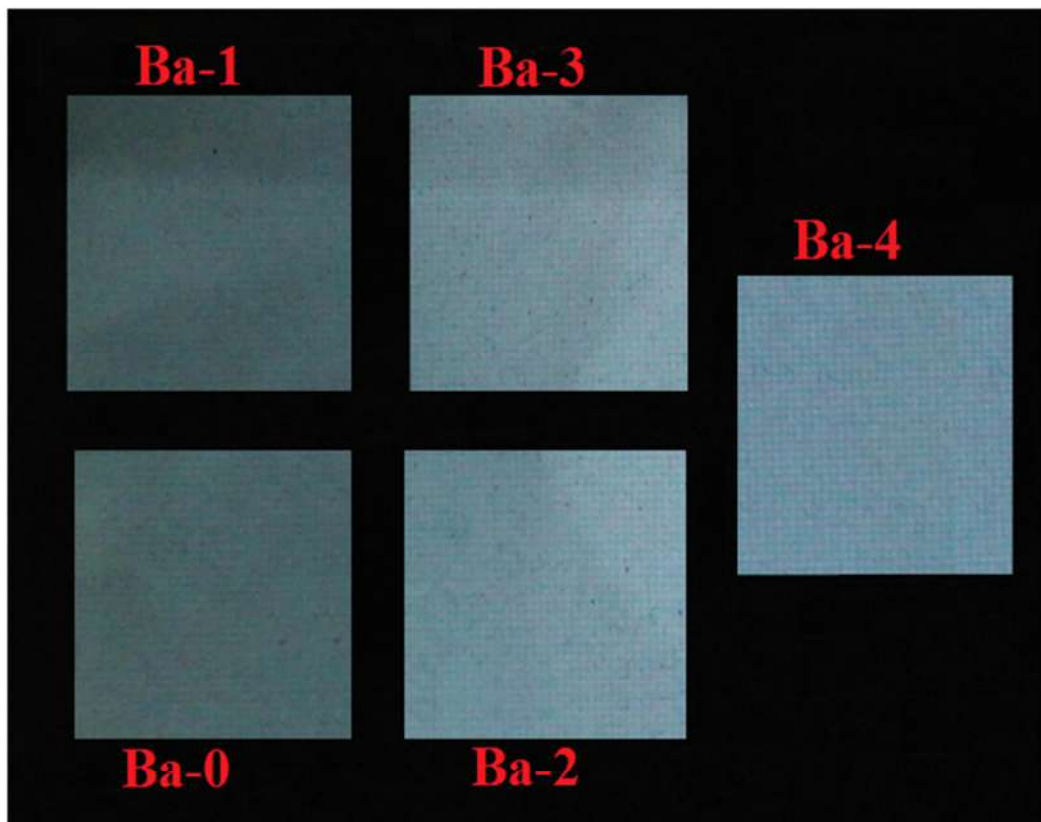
X-ray radiographic image of Ba-0, Ba-1, Ba-2, Ba-3 and Ba-4 bioactive glass samples
